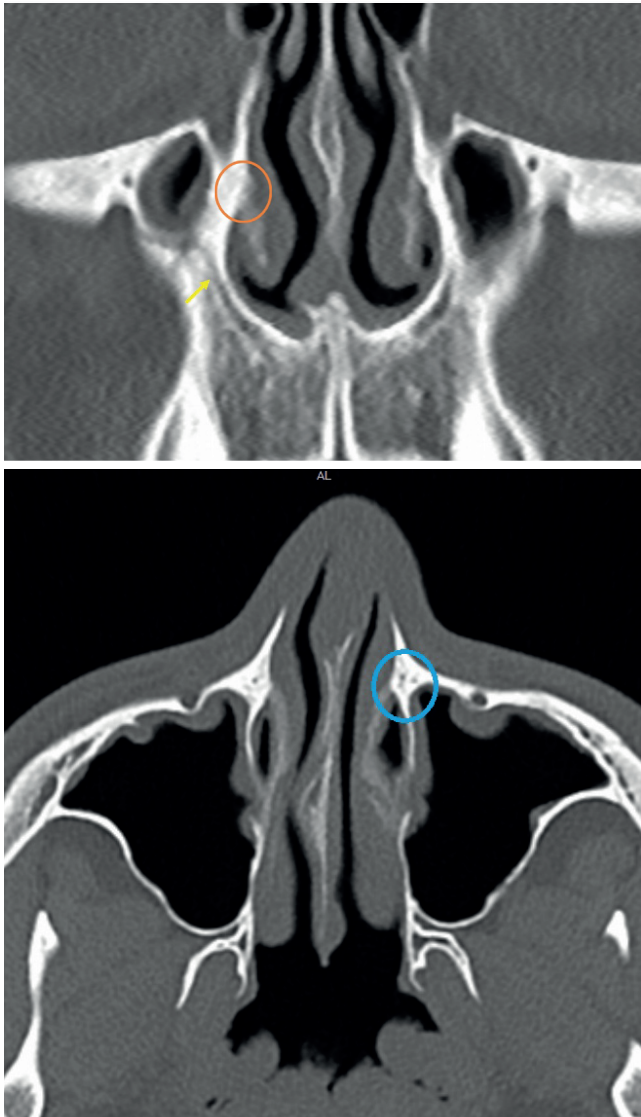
a) Coronal CT depicts the junction of the shoulder of the inferior turbinate with the frontal process of the maxilla (orange circle). The anterior superior alveolar nerve course is defined by the yellow arrow. B) Corresponding axial CT slice of figure 2a, with the blue circle corresponding to the junction of the shoulder of the inferior turbinate with the frontal process of the maxilla.
